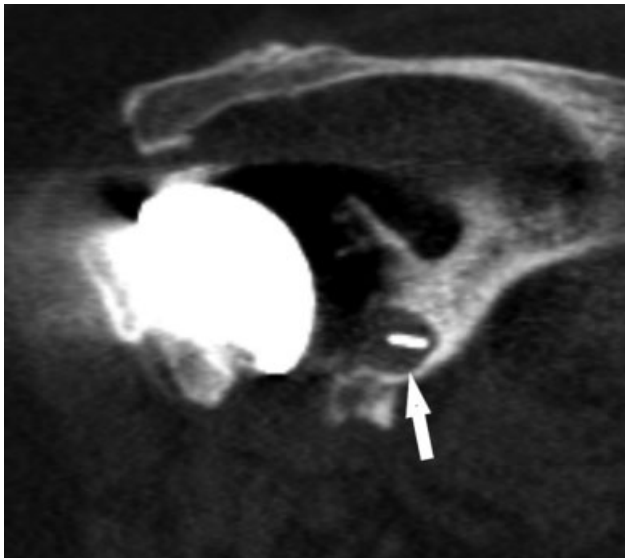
Coronal computed tomography image of a right shoulder showing the absence of osteointegration of the central peg. No bone is seen between the fins of the central peg (arrow).
